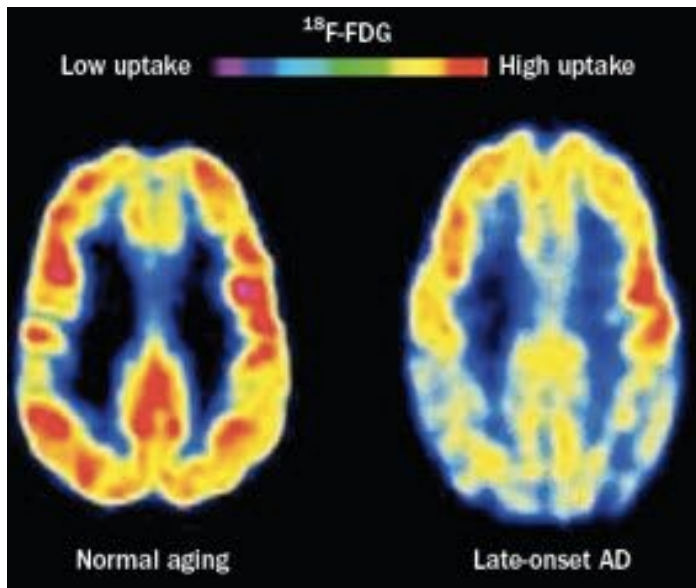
Changes revealed by ¹⁸F-FDG-PET scanning in the brain, patterns characteristic of metabolic activity in cognitively normal individuals and patients with late-onset AD. In comparison with people aging normally (left), individuals with late-onset AD (right) show decreased bilateral glucose metabolism, particularly in the temporal and parietal regions. Abbreviations: AD, Alzheimer disease; FDG, 2-fluoro-2-deoxy-D-glucose; PIB, Pittsburgh compound B.
